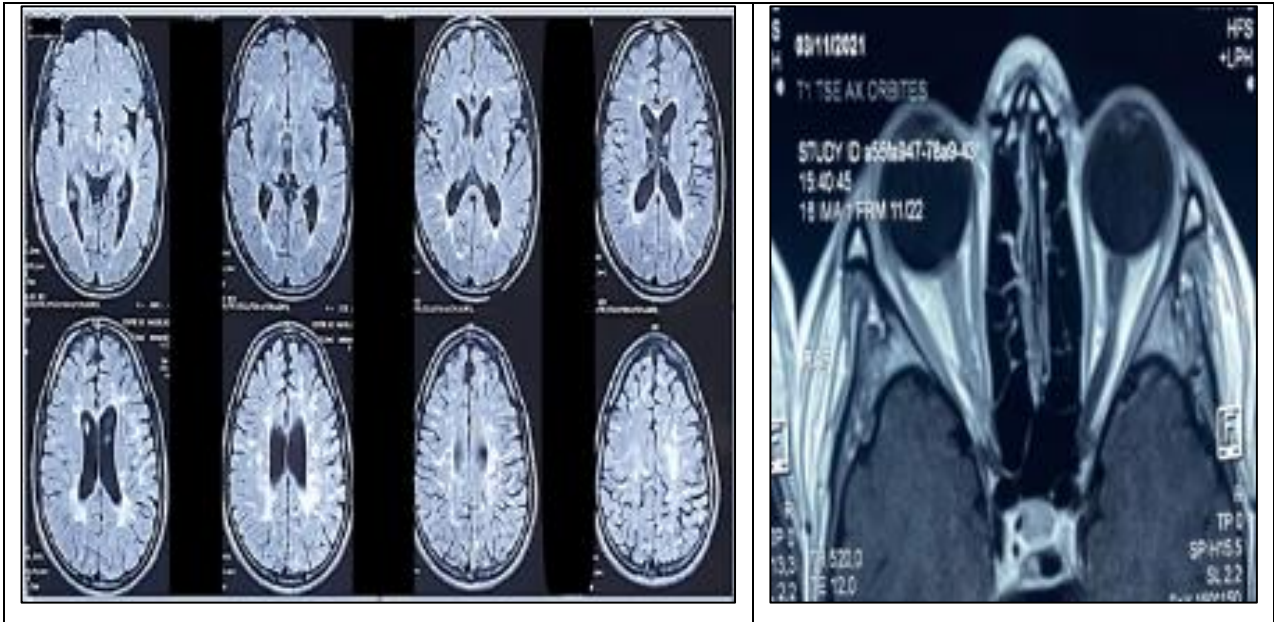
Multiple supra- and infratentorial lesions with optic nerve enhancement on MRI, consistent with demyelinating optic neuritis
